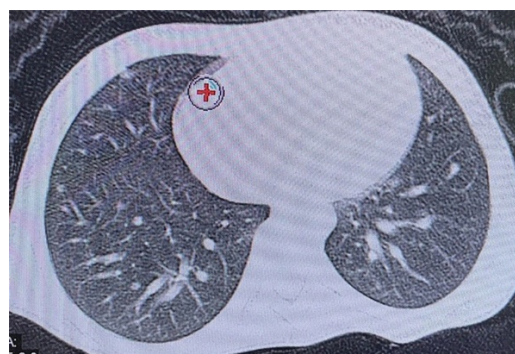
Follow-up chest CT scan image.
